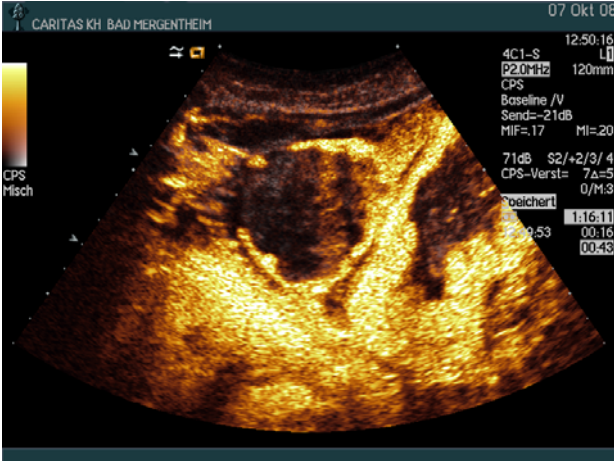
Haemangioma. The typical B-mode appearance is echorich (a) also seen in liver cirrhosis. Contrast-enhanced ultrasound findings are peripheral nodular contrast-enhancement and centripetal fill in with the exception of thrombosed areas and calcifications (iris diaphragm phenomenon).
